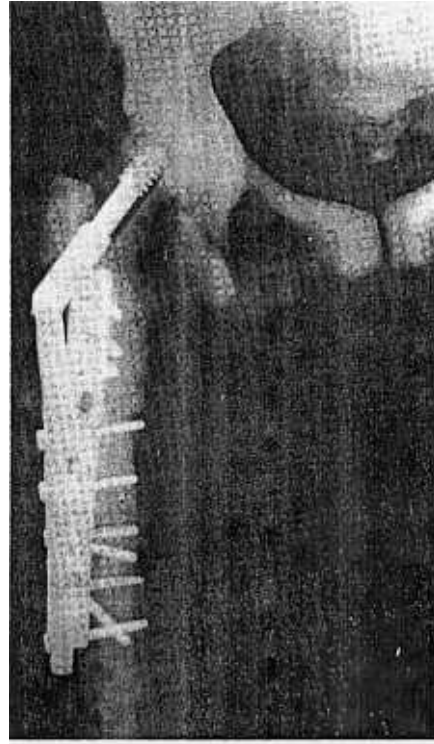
Radiograph two years after the fracture showing osteoarthritis of the hip.
